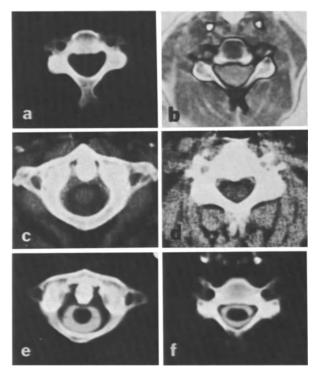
a-f. Normal CT-scans of cervical spine and spinal cord. a Scan at level of C 3 (no enhancement). b Scan at level of C 5 (no enhancement). c Scan at level of atlas showing epidural tissue, subarachnoid space and spinal cord (no enhancement; high contrast window setting). d Scan at level of C 5; spinal cord can be differentiated (i.v. enhancement; high contract window setting). e Scan at level of atlas (metrizamide-enhancement). f Scan at level of C 6 (metrizamide-enhancement)
